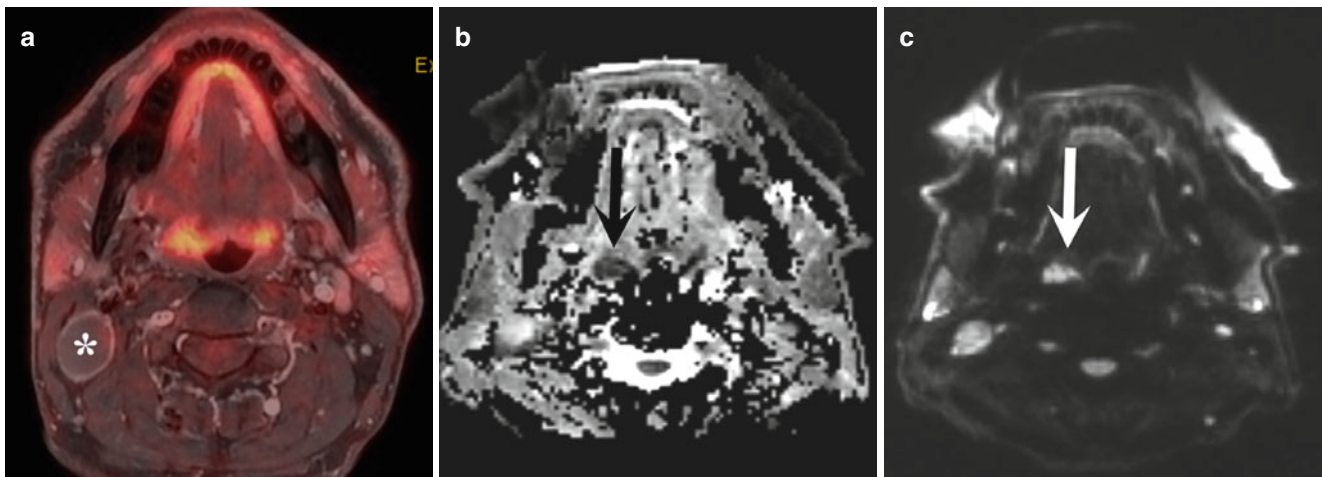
Patient with palpable lump in the neck on the right side. A cystic lymph node metastasis with contrast enhancement of the rim (a, asterisk) is seen on FDG-PET/MR, but no obvious tumor. Diffusion-weighted imaging reveals a lesion with low apparent diffusion
